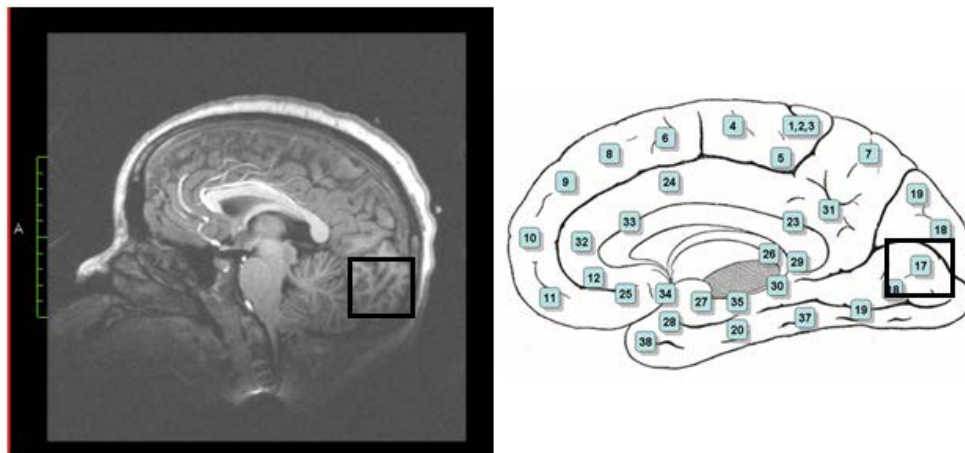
MRI sagittal section of BS's left hemisphere, her structural abnormality of the calcarine sulcus, roughly corresponding to Brodmann's Area 17.
